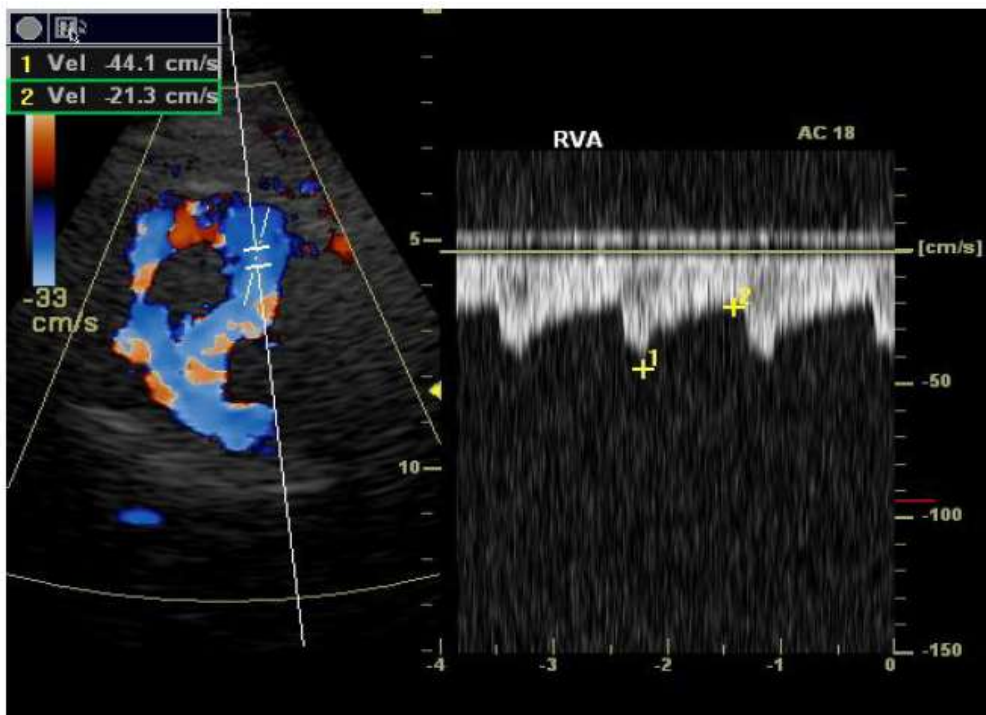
Vertebrobasilar junction, foraminal window, colour-coded Doppler mode.
